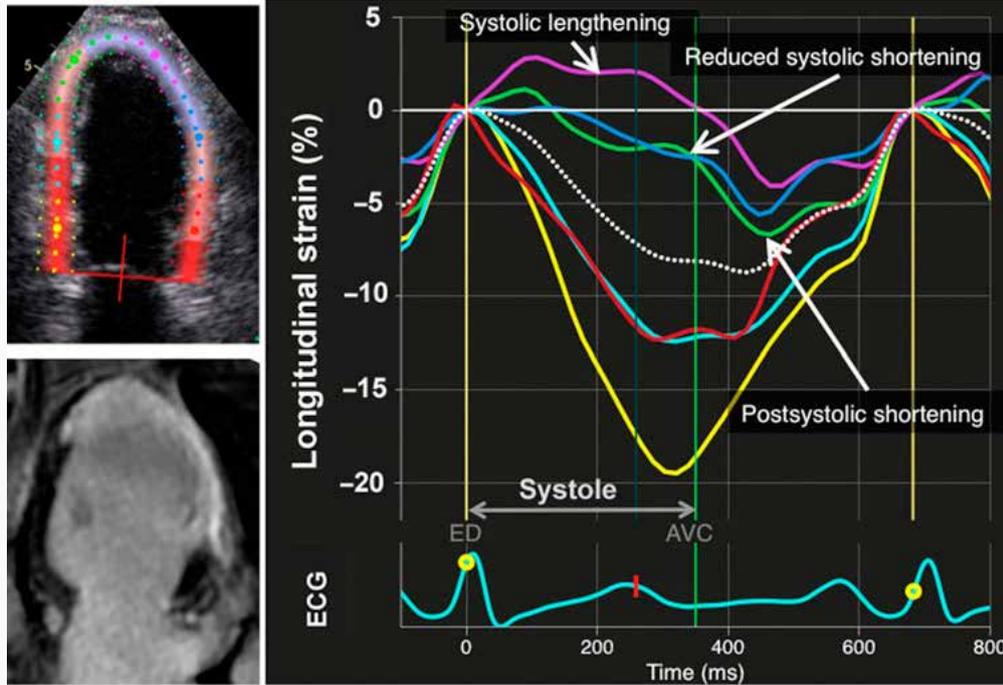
Strain imaging in myocardial infarction. Color-coded regions are superimposed on the ultrasound image in the top left panel. The corresponding strain traces are shown on the right where purple trace is from the center of the infarct region, while the dark blue and green segments are also ischaemic as can be seen from the white scarred myocardium in the late enhancement MRI image in the bottom left panel. The ischaemic segments shorten less than the non-ischaemic segments. Note that strain is percent change of segment length; hence the more negative number means greater shortening. (From OA Smiseth et al. Eur Heart J 2015.)
